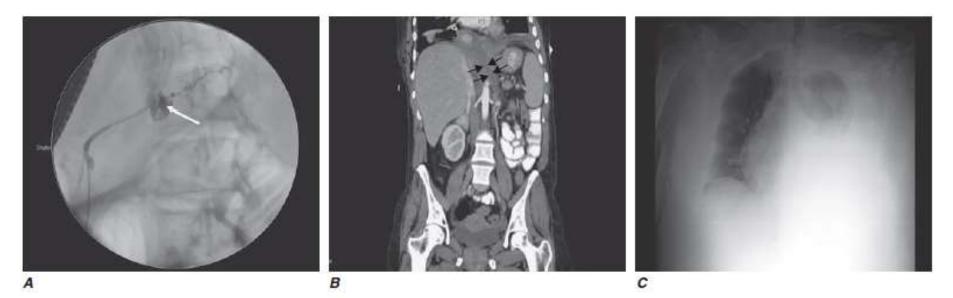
A. Pancreaticopleural fistula: pancreatic duct leak on ERCP. Pancreatic duct leak demonstrated (arrow) at the time of retrograde pancreatogram in a patient with acute exacerbation of alcohol-induced acute or chronic pancreatitis. B. Pancreaticopleural fistula: CT Scan. Contrast-enhanced CT scan (coronal view) with arrows showing fistula tract from
